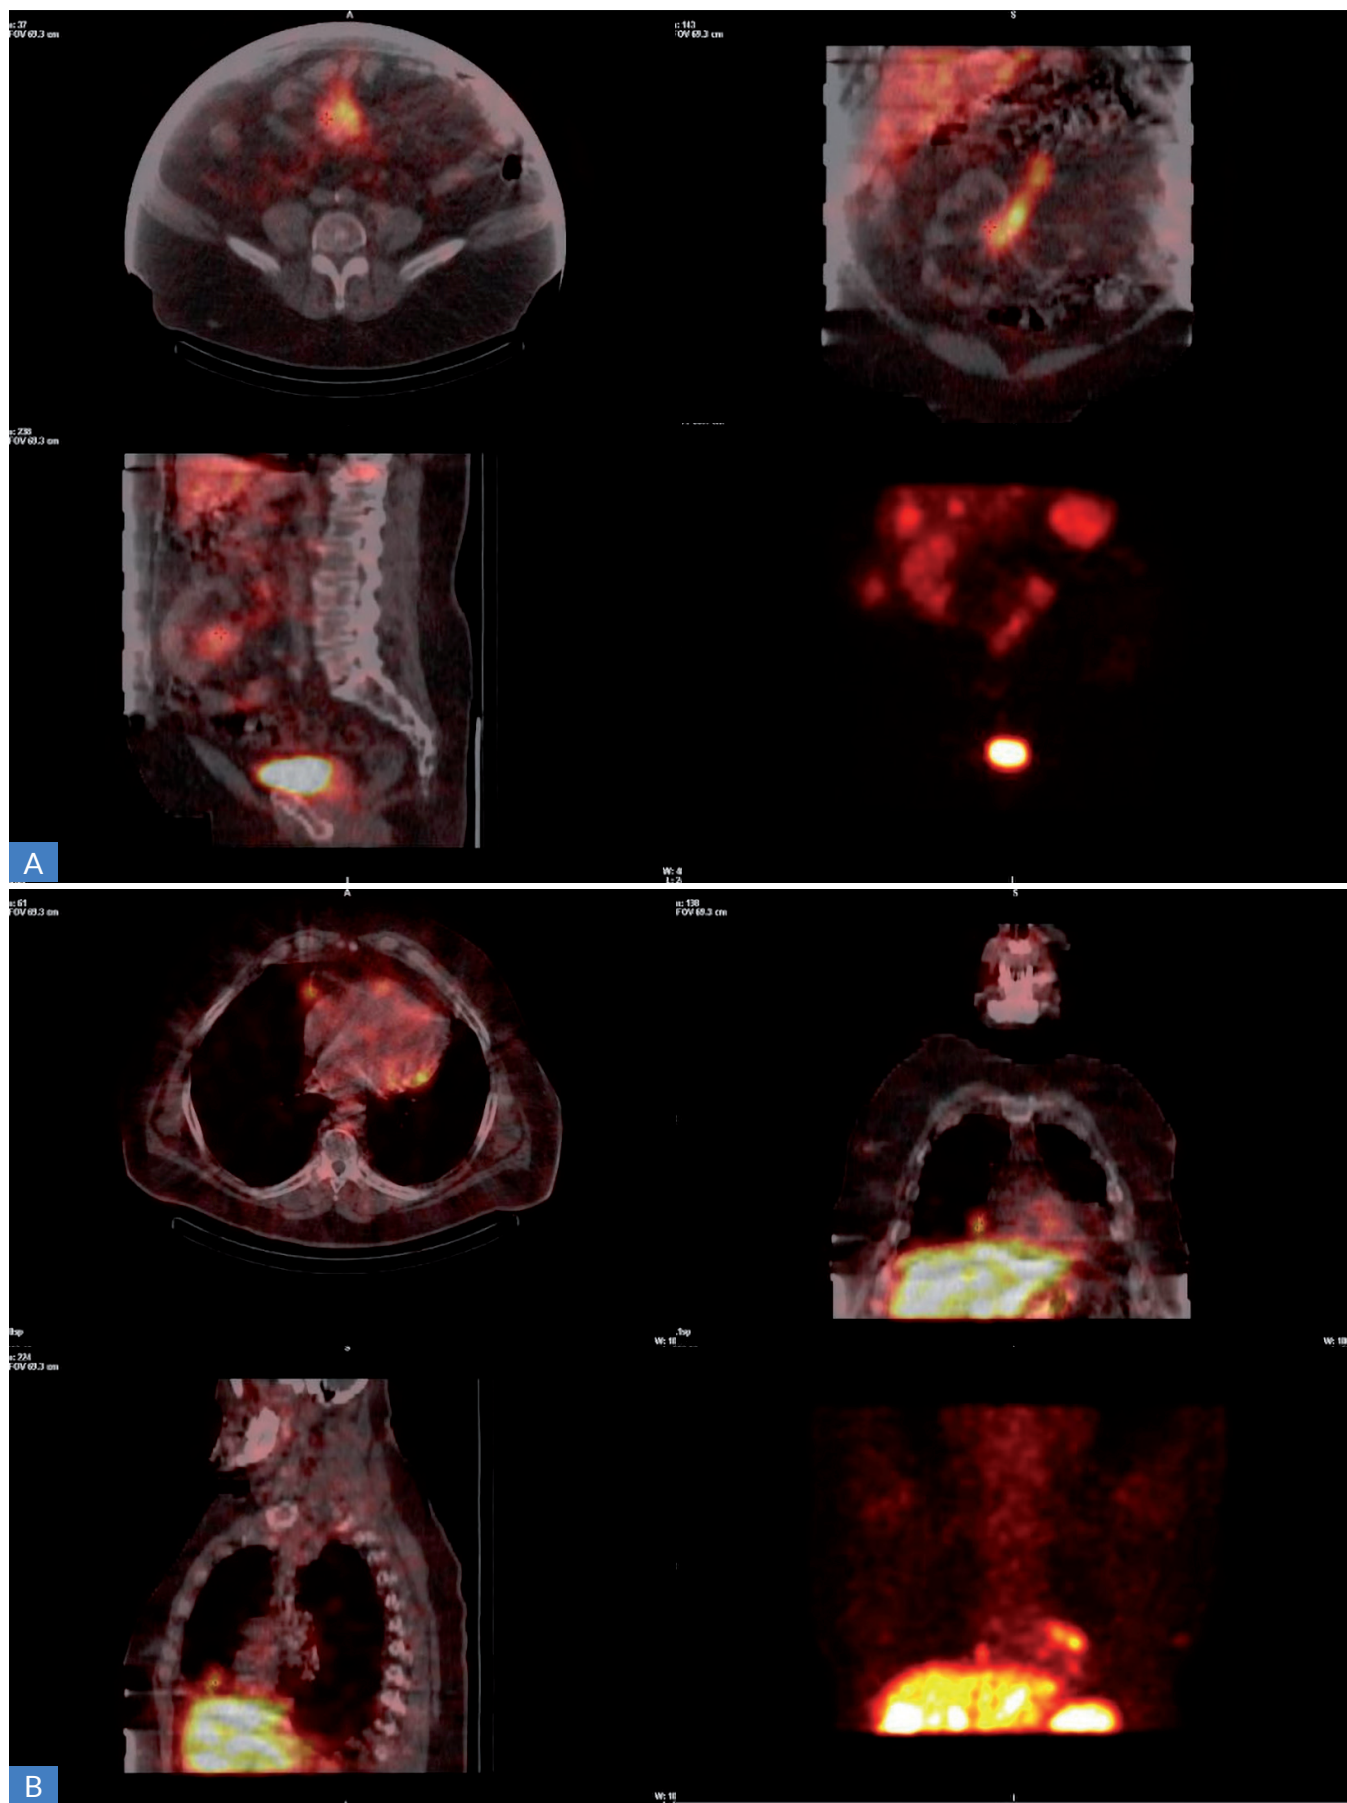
SPECT/CT. Progression of the disease. A. Pathological overexpression in the liver, intestinal mesentery, at the upper pole of the right kidney and in the Th12 vertebral body. B. Additional focal lesions in the heart, orbits, subcutaneous tissue of the chest (in the right breast view); progression of liver lesions
